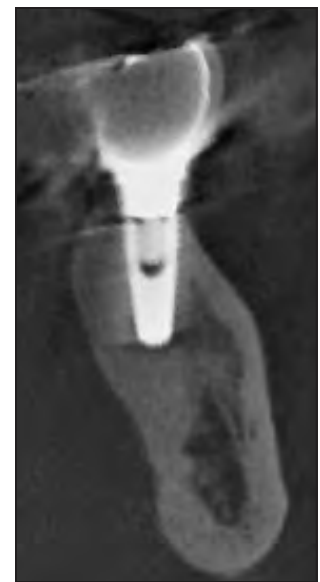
Computed tomography scan 4 years after treatment. The peri-implantitis had been resolved, and the area around the implant had stabilized.
